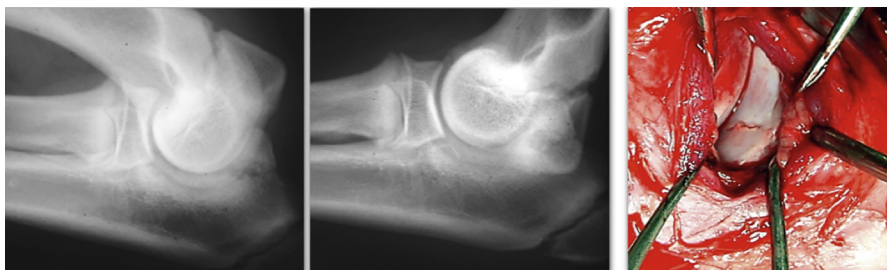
UAP stage I. The process is not fused, but is still firmly attached. Radiographically, the separation line of the anconeal process does not have a complete radiolucency zone and the anconeal process seems to be in its correct position, not dislodged by the humerus in the extended elbow view. Intraoperatively, the anconeal process is connected to the ulna by interposing fibrous tissue and does not appear mobile on palpation, with a minimal separation line.
